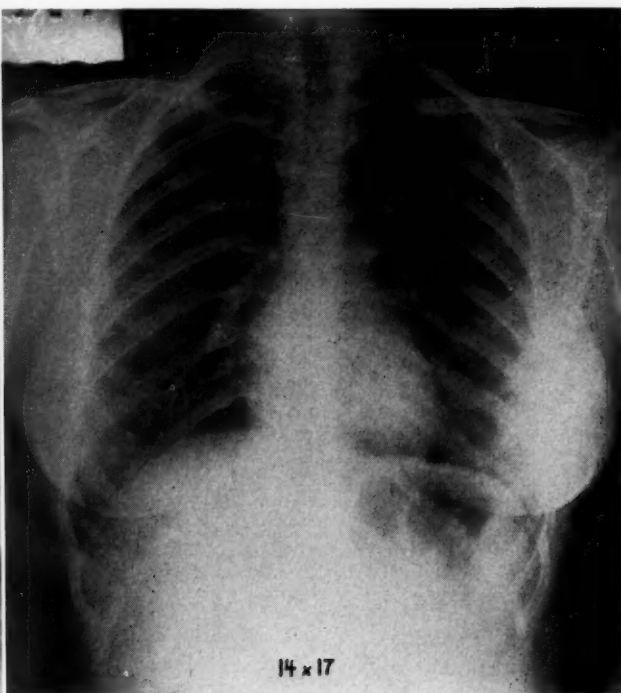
X-ray of Betty Jean S. in January, 1947, showed an unchanged pattern of pulmonary calcifications.
